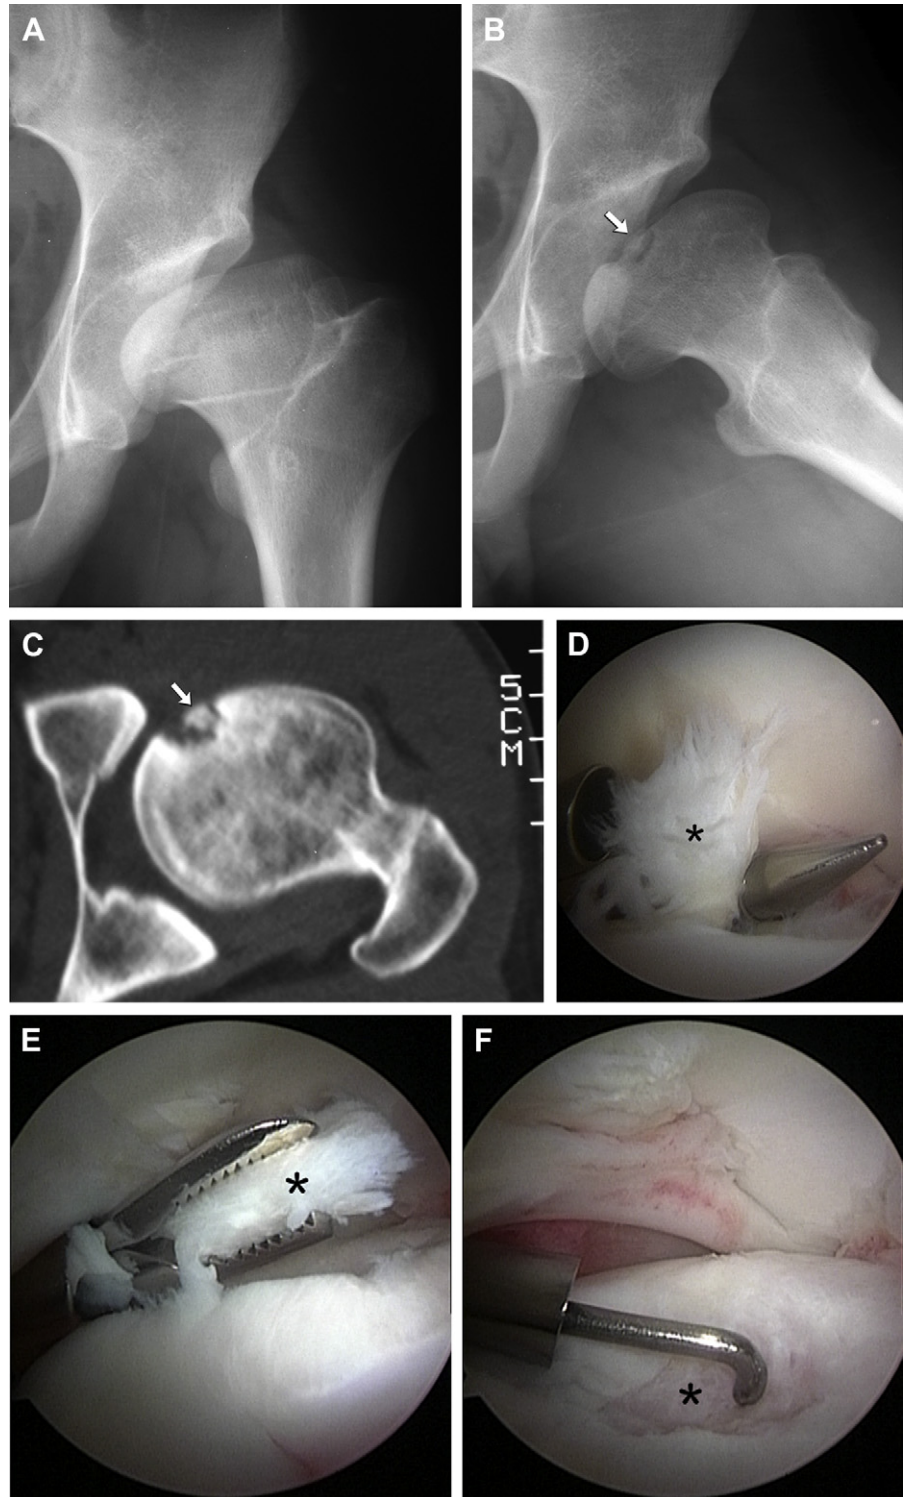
The first Perthes case addressed. A 16-year-old male patient was referred with a diagnosis of a loose body due to OCD associated with LCP disease. (A) The anteroposterior radiograph shows characteristic findings of left-sided Perthes disease. (B) The lateral radiograph suggests the presence of a loose body from the femoral head (arrow). (C) The computed tomography image again suggests a loose bone fragment (arrow). (D) The arthroscopic view from the posterolateral portal shows an unstable articular fragment (asterisk). (E) The unstable articular fragment (asterisk) is being retrieved with a grasper. (F) The bone fragment within the femoral head crater is being probed. It is firmly fixed by fibrous tissue (asterisk) and not the source of the patient's symptoms.
